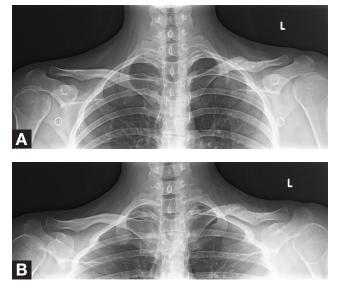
Eighteen months after injury. (A) Final bilateral anteroposterior radiograph. (B) Final bilateral serendipity radiograph. Radiolucent implants are still visible within left clavicle.
